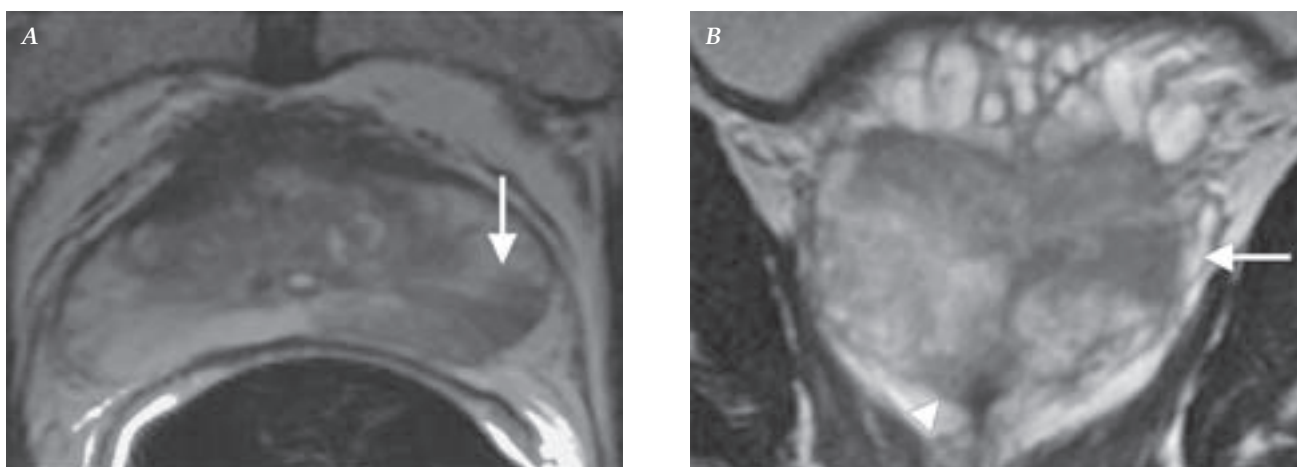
Clinical T1c non-palpable lesion. Endorectal MR images from a patient with non-palpable, clinical stage T1c prostate cancer. Axial (A) and coronal (B) images show a large lesion in the left peripheral zone (arrows); coronal image (B) also shows a second lesion (arrowhead) in the right apex.
